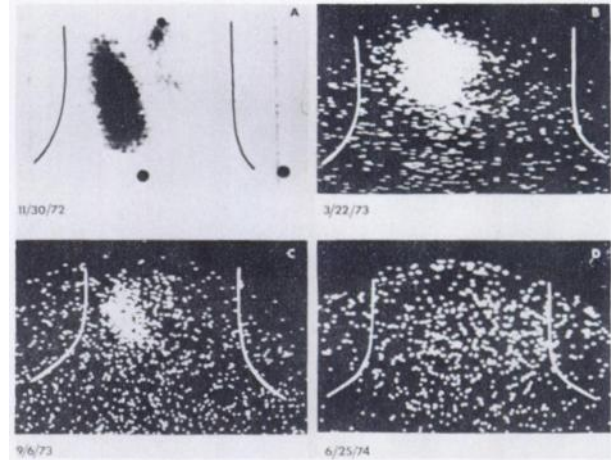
(A) Scintigram of thyroid 24 hr after oral administration of I-131. Large nonfunctional mass is present in left lobe of thyroid. (B) Scintigram of thyroid 30 min after i.v. administration of [^{99m}Tc] pertechnetate. Two months after surgical removal of left lobe, isthmus, and subtotal removal of right thyroid lobe, only remnant of right lobe remains. Triiodothyronine (Cytomel $^{\text{®}}$) therapy was discontinued 2 weeks prior to scanning to increase endogenous thyrotropin secretion. (C) Thyroid scintigram 8 months after administration of 80 mCi of I-131. Cytomel $^{\text{®}}$ was discontinued 3 weeks prior to scanning. Thyroid remnant remains. (D) Thyroid scintigram 9 months following second therapeutic dose, 150 mCi of I-131. Cytomel $^{\text{®}}$ therapy was discontinued 3 weeks before scanning. Thyroid remnant has disappeared.
